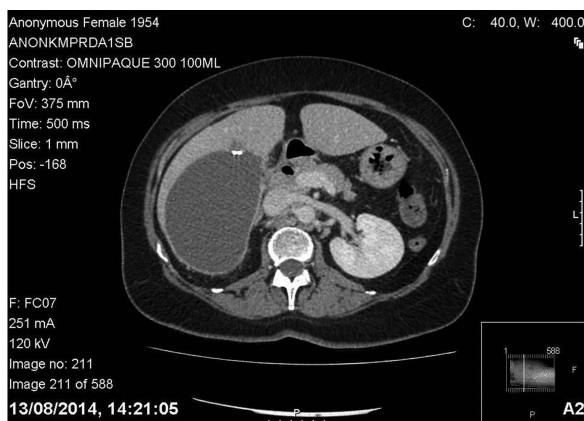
Contrast-enhanced CT of the abdomen and pelvis demonstrating a large subcapsular haematoma with evidence of pneumobilia in biliary tree.
